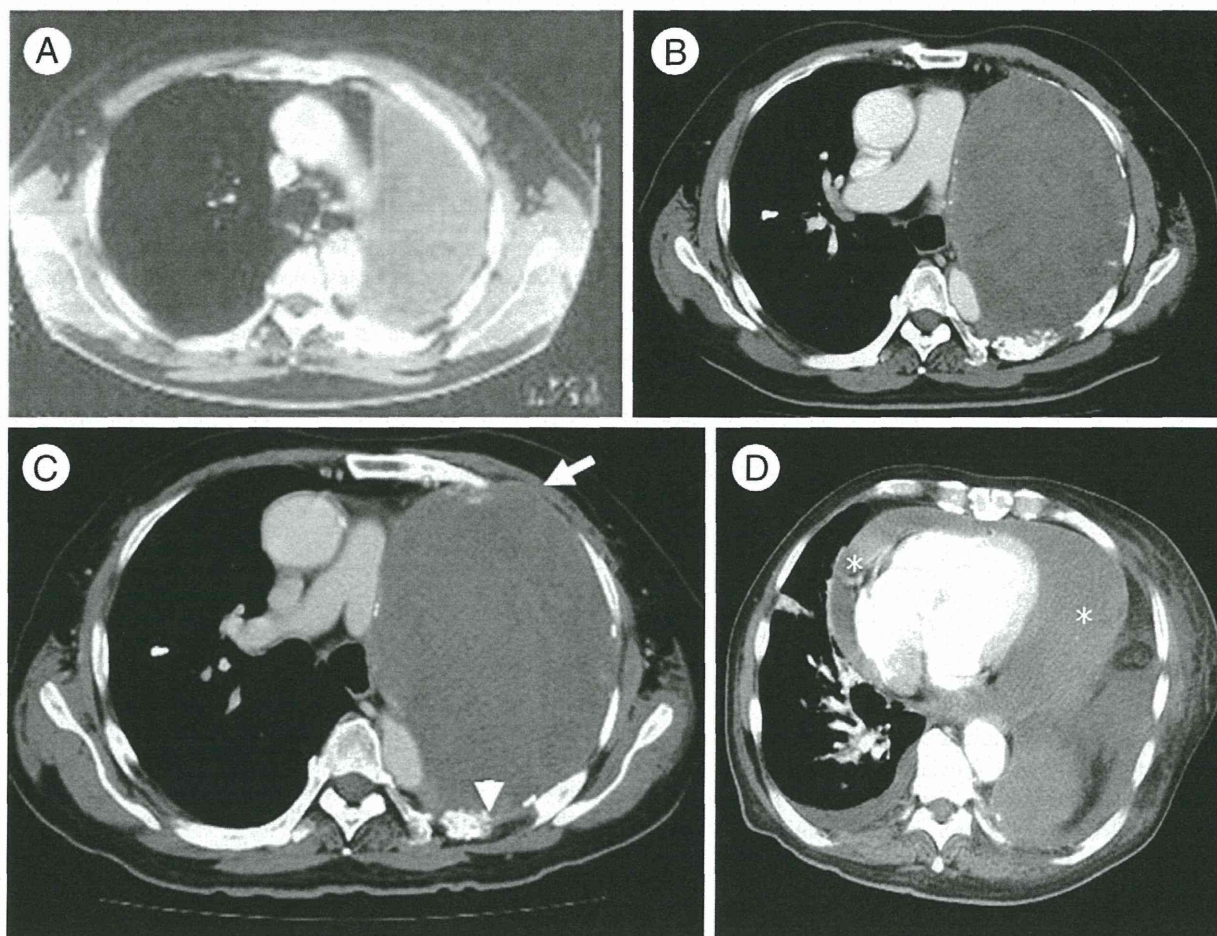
A, Chest CT scan taken 8 years after left pneumonectomy. Left thoracic space shows soft tissue attenuation without signs of cancer recurrence. B, Chest CT scan taken 17 years after left pneumonectomy. A huge mass is occupying the left hemithorax and compressing the descending aorta. Compared with A, its growth is apparent. The CT findings are compatible with those of CEH. C, Two years and 8 months after the first detection of CEH. In addition to similar findings as B, invasion to the chest wall (arrow) and osteolytic change (arrow head) is observed. D, Just before the patient's death. The heart is directly surrounded and compressed by the lesion (*).
